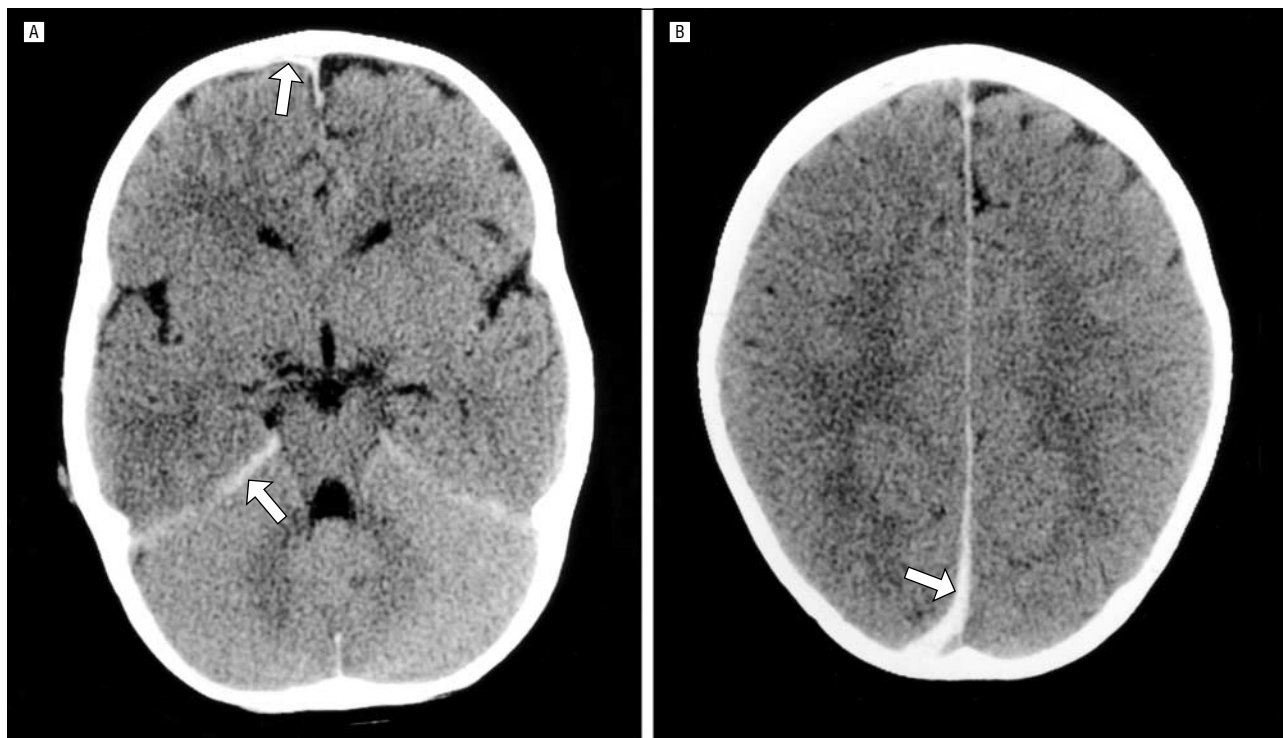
Common computed tomographic (CT) findings with intentional trauma. An 18-month-old boy was shaken and thrown to the floor by his mother's boyfriend 3 hours prior to the CT examination. Subsequent CT imaging (not shown) demonstrated worsening edema over the next few days. The child died 5 days later. A, Note the acute convexity subdural hemorrhage adjacent to the right frontal lobe and along the tentorium (arrows). B, A more superior CT image shows a right posterior interhemispheric subdural hematoma (arrow).
